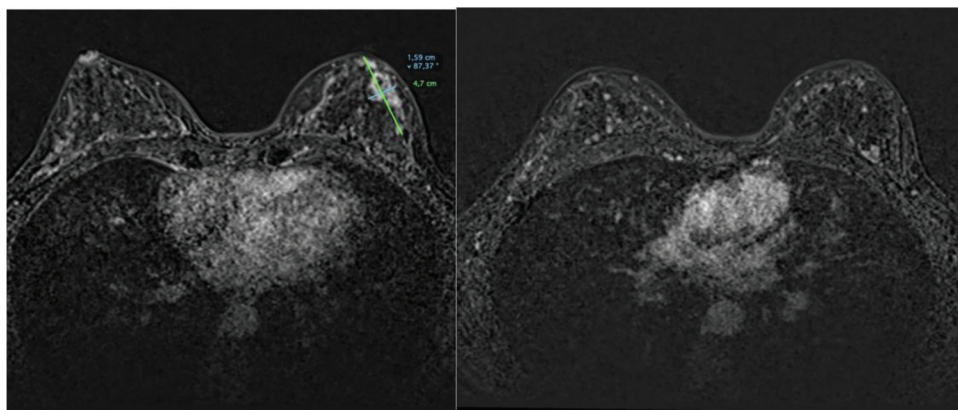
MRI images depict masses with multifocal and multicentric contrast enhancements (marked by the two lines).
